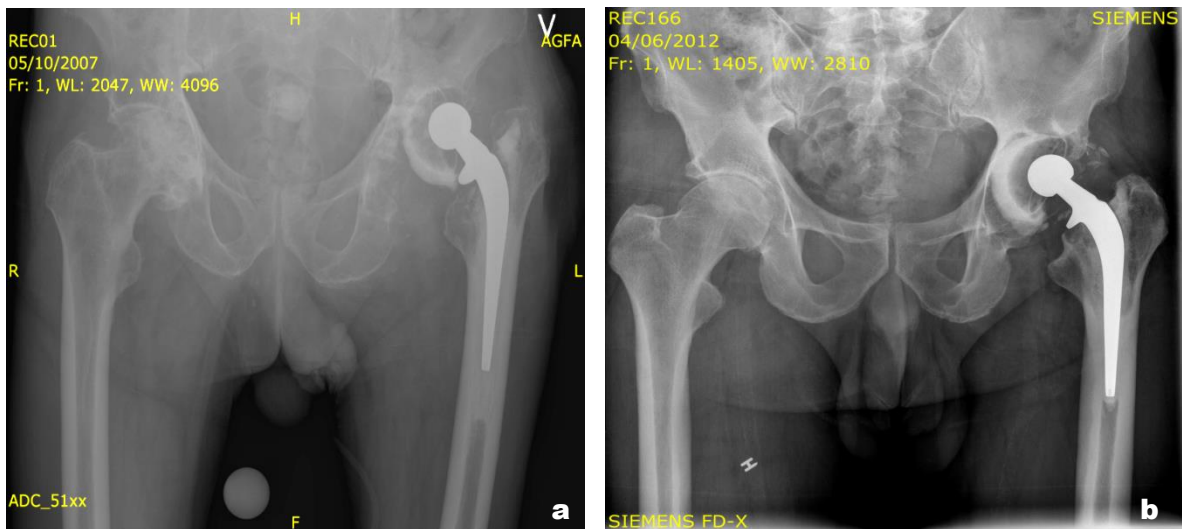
Examples of X-rays presented rotated cup (a. Rec1; b. Rec166)
